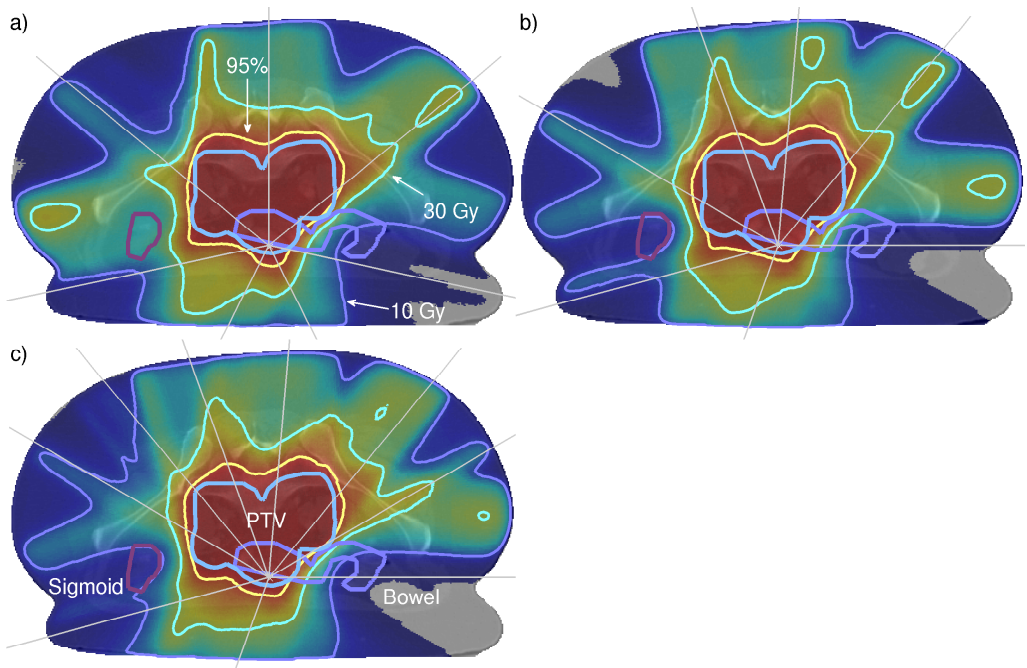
Axial CT-slice of the cervical cancer case with dose distributions and beam directions. a) 7 beam clinical beam arrangement, b) 7 beam optimized coplanar plan, c) 9 beam optimized coplanar plan.
